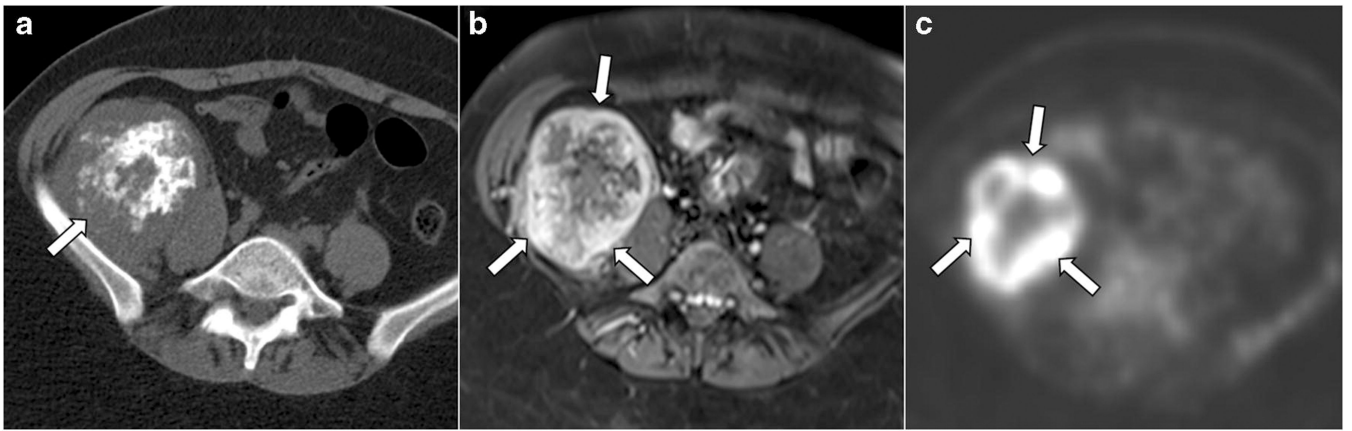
Primary soft tissue retroperitoneal mesenchymal chondrosarcoma with biphasic pattern in a 34-year-old woman. Axial non-contrast CT (a) shows a mass (arrow in a) in the right iliac fossa inseparable from the right iliacus muscle and a biphasic imaging appearance with a distinct calcified (central) and non-calcified (periphery) components. Post-contrast axial T1-weighted fat-suppressed image (b) shows a thick enhancing peripheral rim (arrows in b) corresponding to the non-calcified components on the CT. The mass is avid on axial PET (c) with a mean SUVmax of 13.6. Note that the periphery of the mass, corresponding to the non-calcified components, shows the highest uptake on PET (arrows in c).
